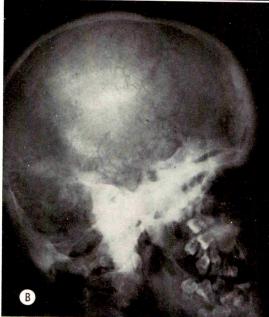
(A and B) Roentgenograms showing the typical findings of craniometaphyseal dysplasia (see text).
